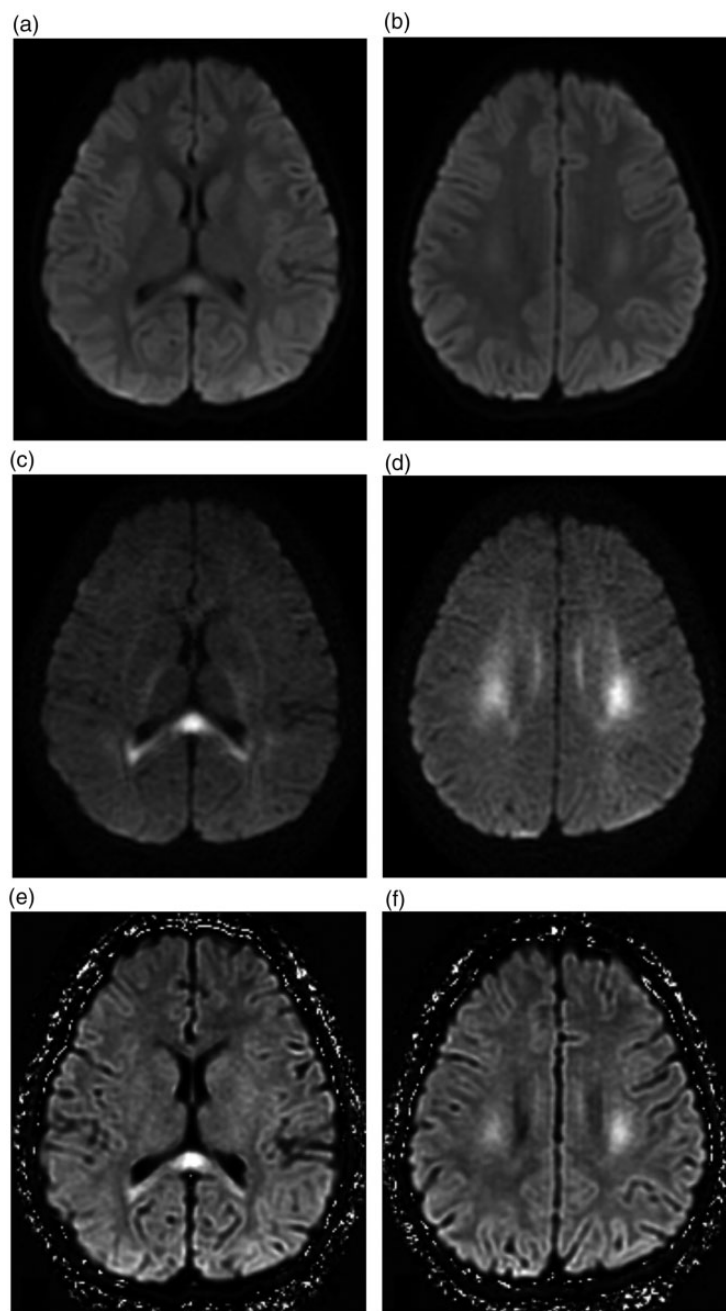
MRI of a 73-month-old boy with mild encephalopathy with reversible lesions in the splenium type 2 on day 5 of the illness. (a, b) Acquired DWI (aDWI) $b = 1000$, (c, d) aDWI $b = 3000$, (e, f) cDWI $b = 3000$. cDWI $b = 3000$ (e, f) and aDWI $b = 3000$ (c, d) show higher signal intensity in the splenium of the corpus callosum and bilateral centrum semiovale compared to that of aDWI $b = 1000$ (a, b).
